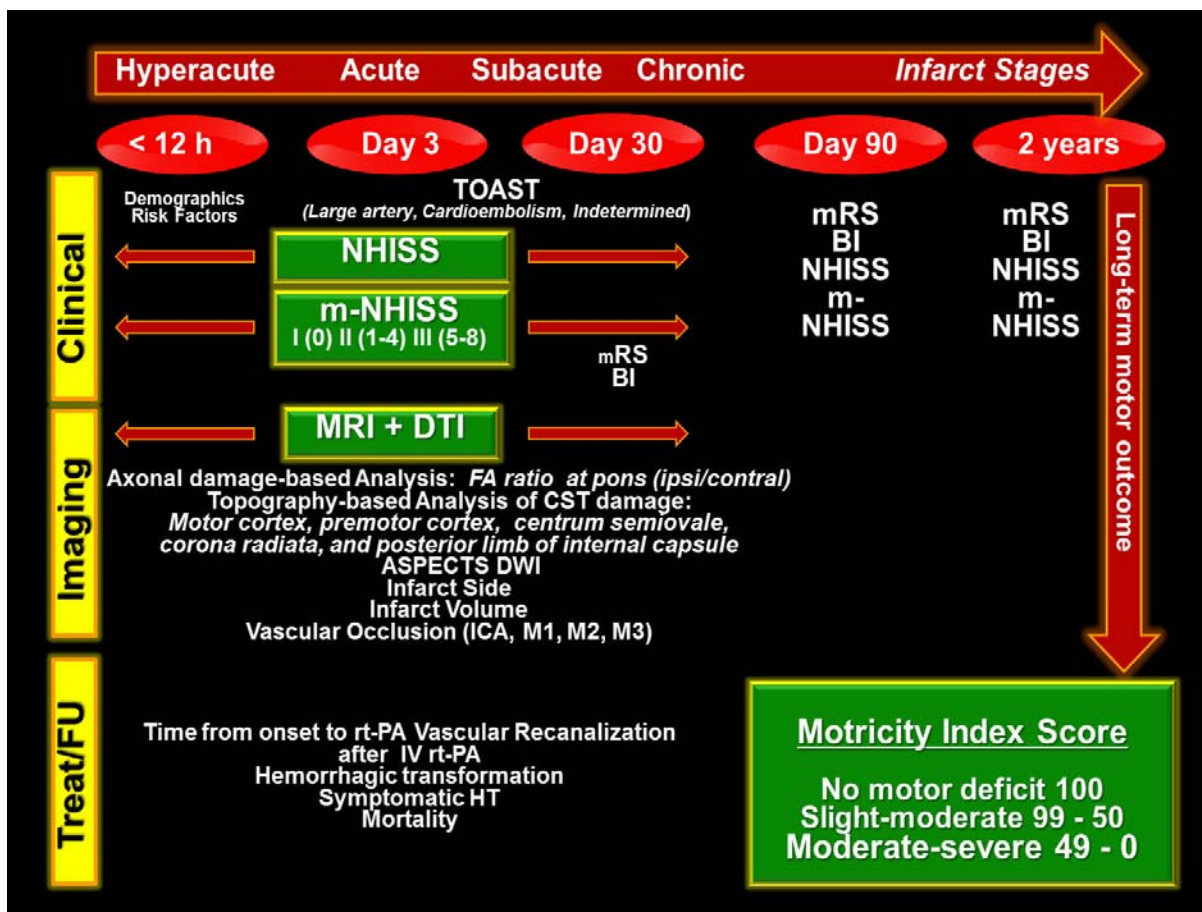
Clinical and MRI protocol from patient's admission to 2 years follow-up.
